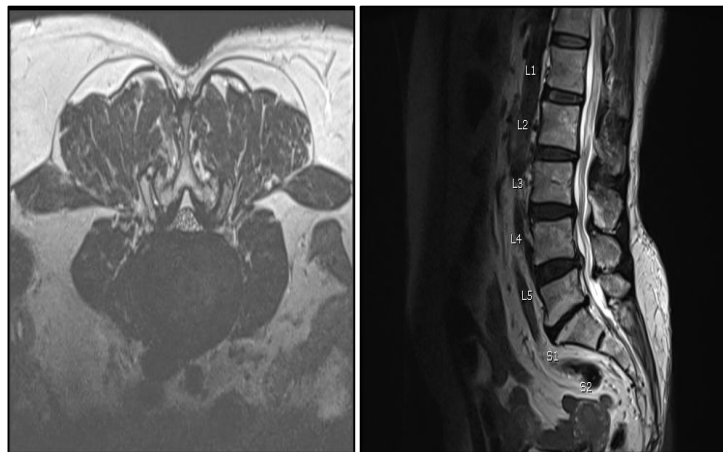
Multilevel Degenerative Changes with Disc Bulges in a 68-Year-Old Female. Sagittal (Right) And Axial (Left) T2-Weighted MRI Images of the Lumbar Spine Demonstrate Degenerative Disc Changes with Modified Pfirrmann Grade 4 at the L1/L2 Level, Grade 5 at the L3/L4 and L4/L5 Levels, and Grade 7 at the L5/S1 Level. Associated Posterior Disc Bulges are noted at the L4/L5 and L5/S1 Levels
